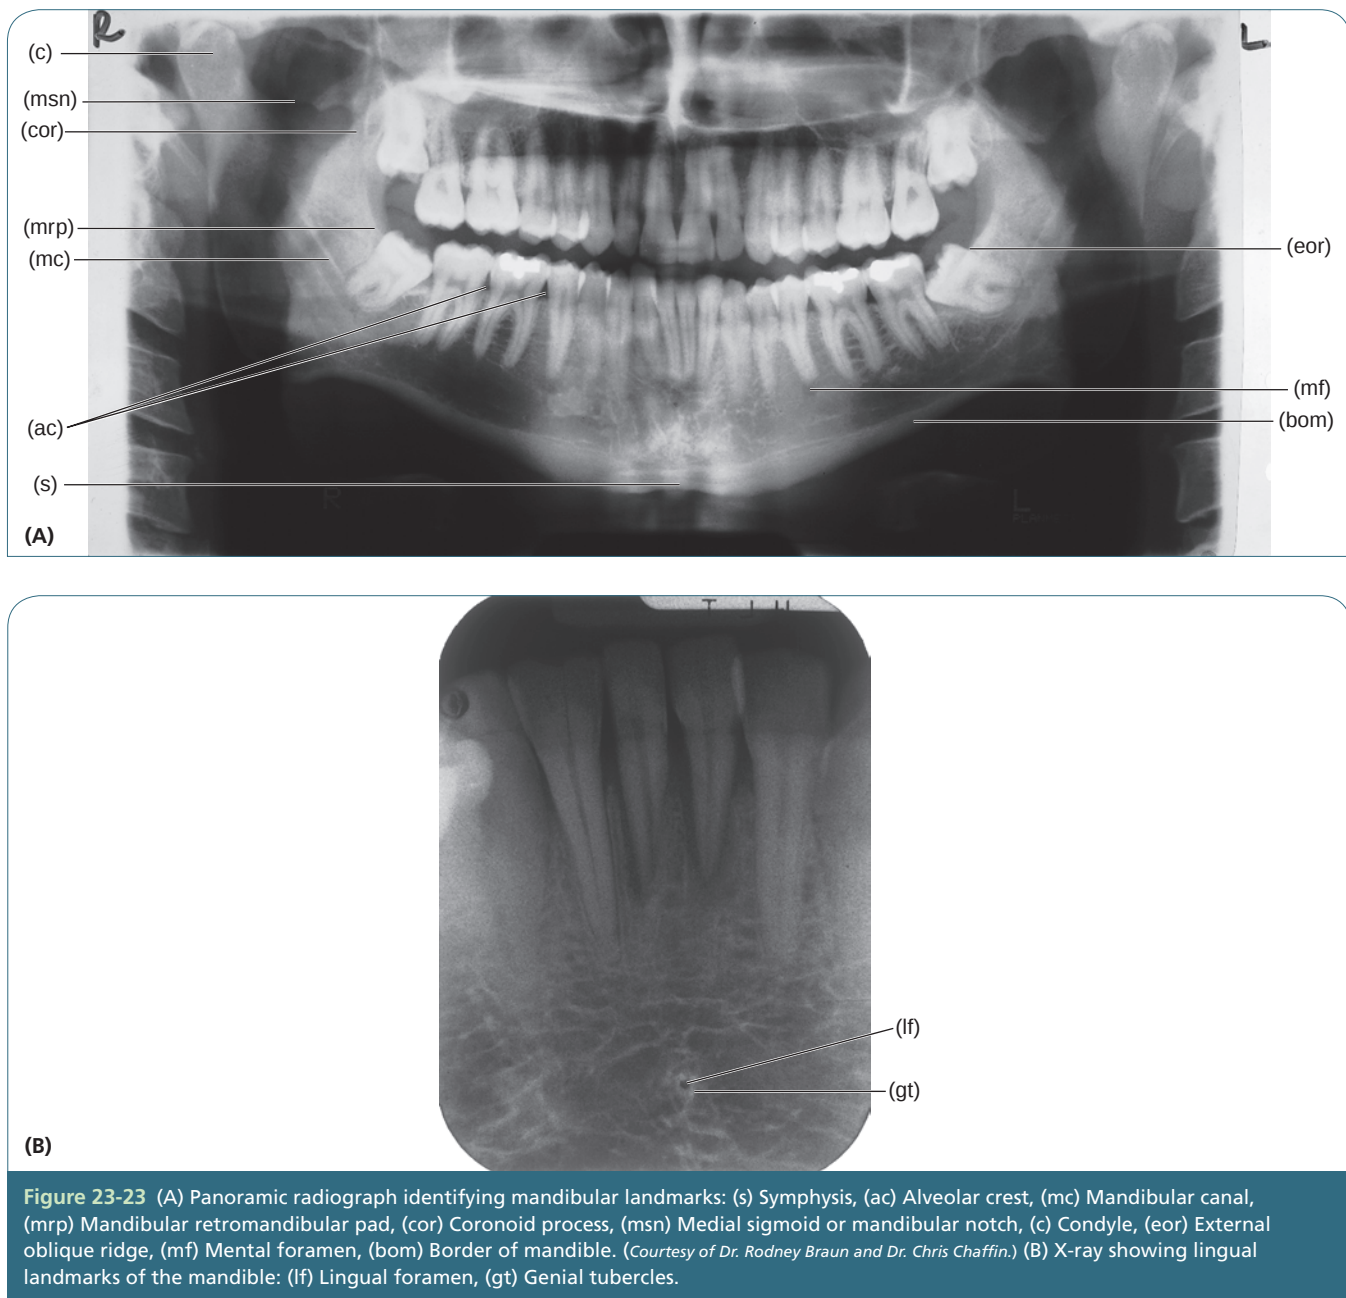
(A) Panoramic radiograph identifying mandibular landmarks: (s) Symphysis, (ac) Alveolar crest, (mc) Mandibular canal, (mrp) Mandibular retromandibular pad, (cor) Coronoid process, (msn) Medial sigmoid or mandibular notch, (c) Condyle, (eor) External oblique ridge, (mf) Mental foramen, (bom) Border of mandible. (Courtesy of Dr. Rodney Braun and Dr. Chris Chaffin.) (B) X-ray showing lingual landmarks of the mandible: (lf) Lingual foramen, (gt) Genial tubercles.
